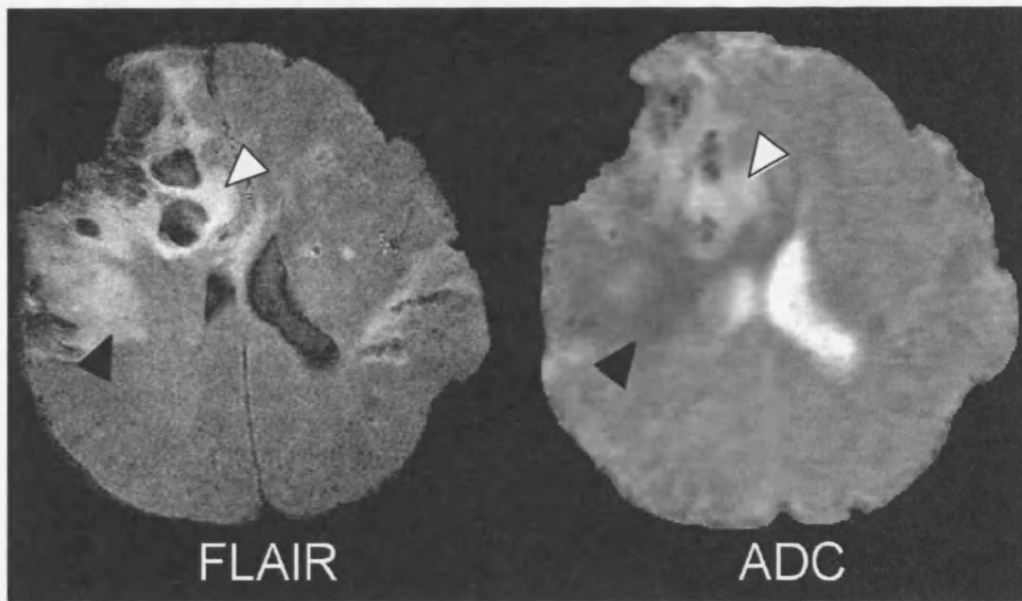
FLAIR hyperintensity associated with mixed ADC values
